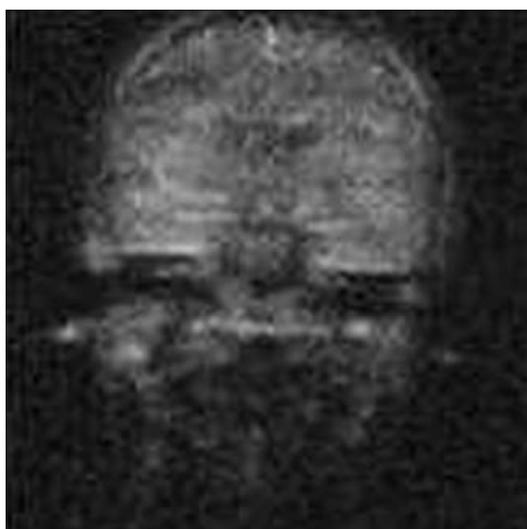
False-negative HASTE DWI. The coronal HASTE DWI (b=1000) does not show a hyperintense lesion suggestive of cholesteatoma. Follow-up surgery revealed a thin, diffuse 4–5 mm cholesteatoma with a facial and supratubal recess. Motion artifacts were responsible for the missed cholesteatoma on the HASTE DWI in this patient.
